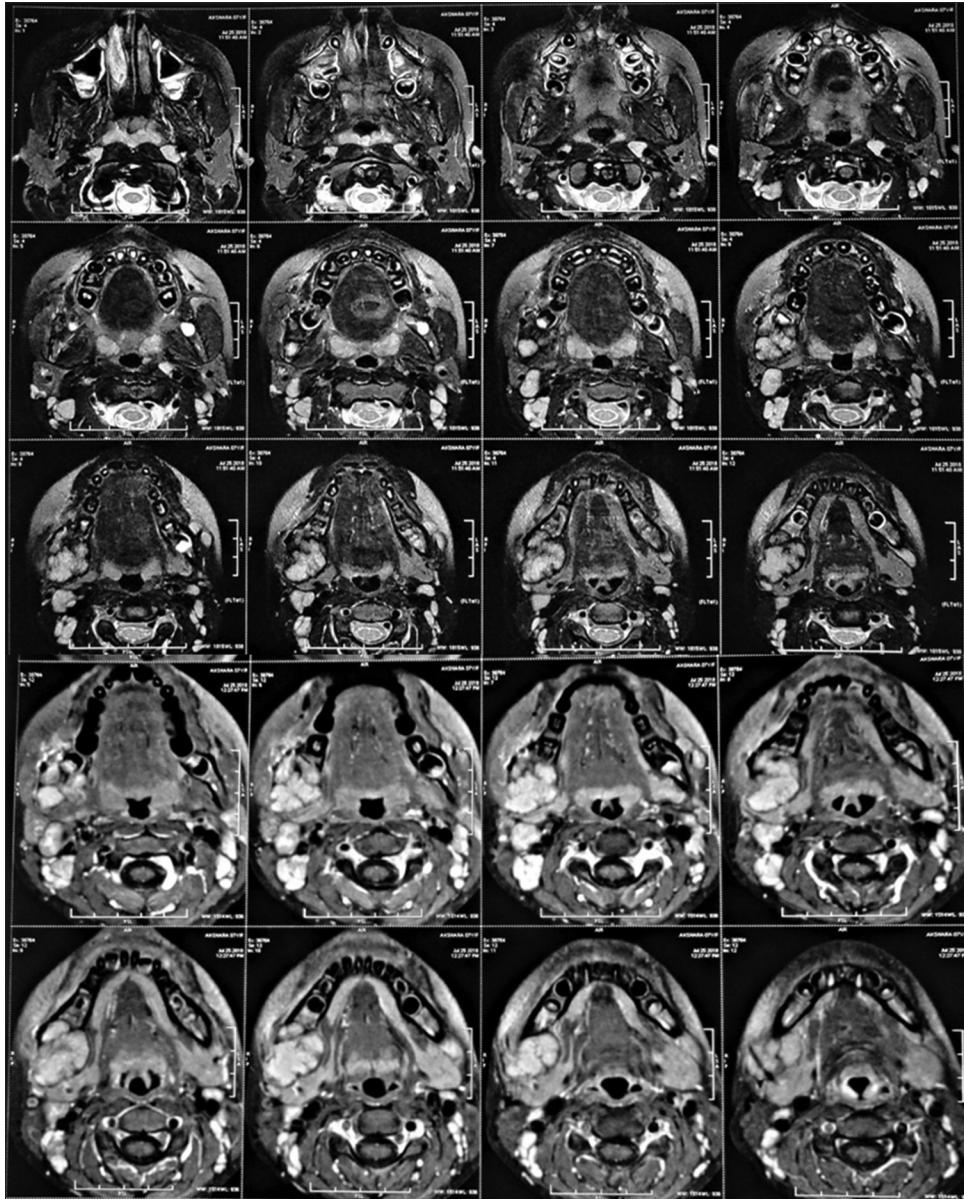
Magnetic resonance imaging of the lesion (axial sections) showed evidence of a 3.3 cm × 2.5 cm × 3.4 cm well-defined, expansile, mild to moderately enhancing lobulated T1 hypointense and T2 iso to hyperintense lesion in the right angle of the mandible with cortical thinning and cortical breaches, causing mild compression of the submandibular gland
